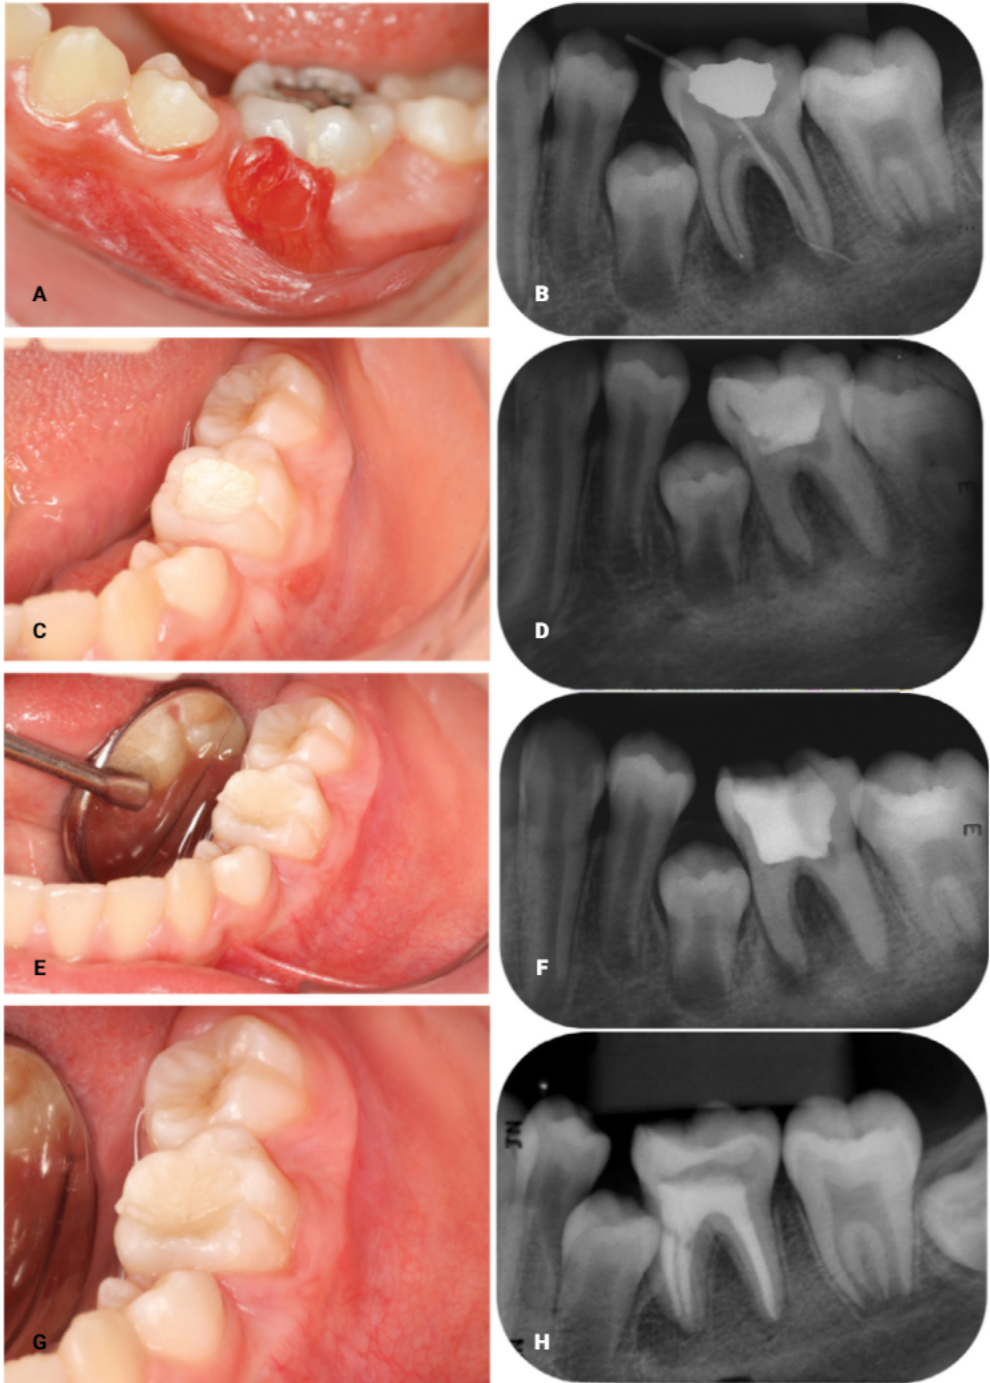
Case 2. (A) Initial appearance of the lesion; (B) mapping of the fistula; (C) clinical and (D) radiographic appearance of the lesion after 15 days with intracanal dressing maintenance of CPMC-enriched calcium hydroxide; (E) clinical appearance; and (F) radiographic evidence of bone reorganization after 45 days; (G) total regeneration of tissue at the lesion site; and (H) evidence of bone repair after 6 months.
